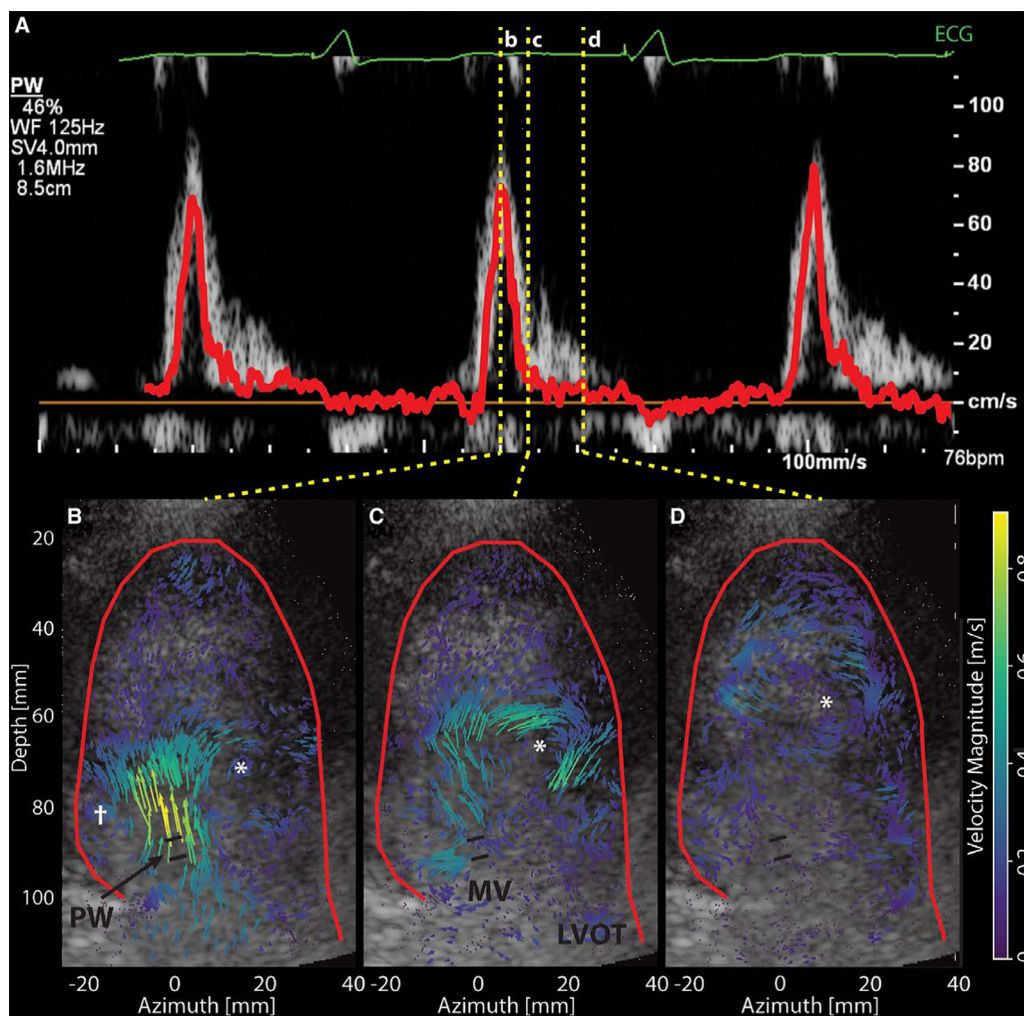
High-frame-rate echoPIV in the left ventricle. (a) Mean echoPIV velocity (red) overlaid on pulsed-wave Doppler spectrogram obtained in the mitral valve region (see PW in b). (b–d) Velocity map visualization during diastolic filling (temporal locations marked in a), revealing the high-velocity transmitral jet entering the ventricle (b) and central clockwise vortex (*) that starts basally and migrates apically (c, d). MV = mitral valve, LVOT = left ventricular outflow tract. A female patient with dilated cardiomyopathy and dual-chamber pacemaker defibrillator (DDD-ICD); frame rate = 1225 Hz. Reprinted with permission from Voorneveld et al. (2019).
